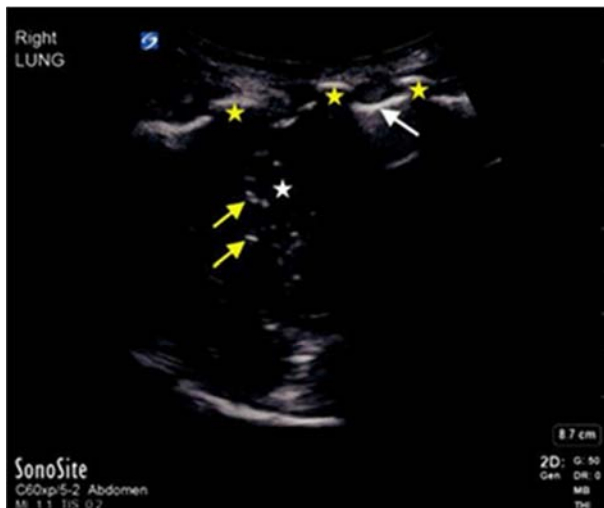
Ultrasound image showing right lung consolidation with hepatization (white star), air bronchograms (yellow arrows); pleural line (white arrow), ribs (yellow star) [41].
